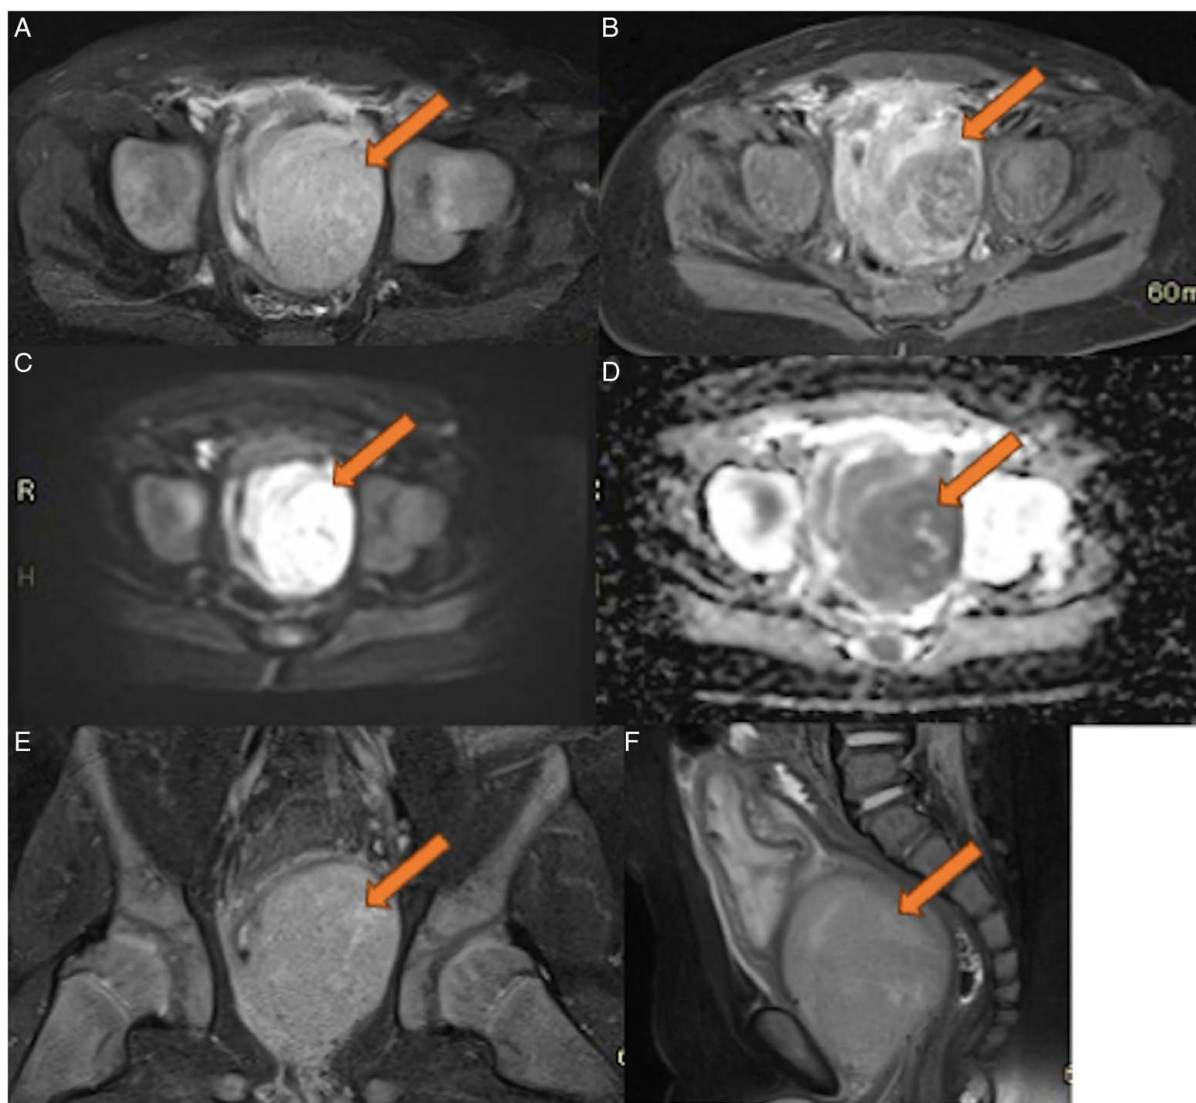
MR imaging of the abdomen with a gadolinium-based contrast agent reveals a large, well-circumscribed, heterogeneous, expansive mass located inferior and posterior to the urinary bladder. The lesion appears predominantly hyperintense on T2-weighted sequences (A, E, F) and demonstrates partial enhancement after contrast administration, with a centrally less enhancing area likely corresponding to necrosis (B). On diffusion-weighted imaging (C, D), the lesion shows restricted diffusion with corresponding low signal intensity on the ADC map. The MR characteristics of the lesion are compatible with a malignant process. Considering the lesion and the fact that a normal prostate cannot be clearly visualized, the most probable diagnosis is a prostatic tumor, which was likely the cause of the postrenal AKI.
